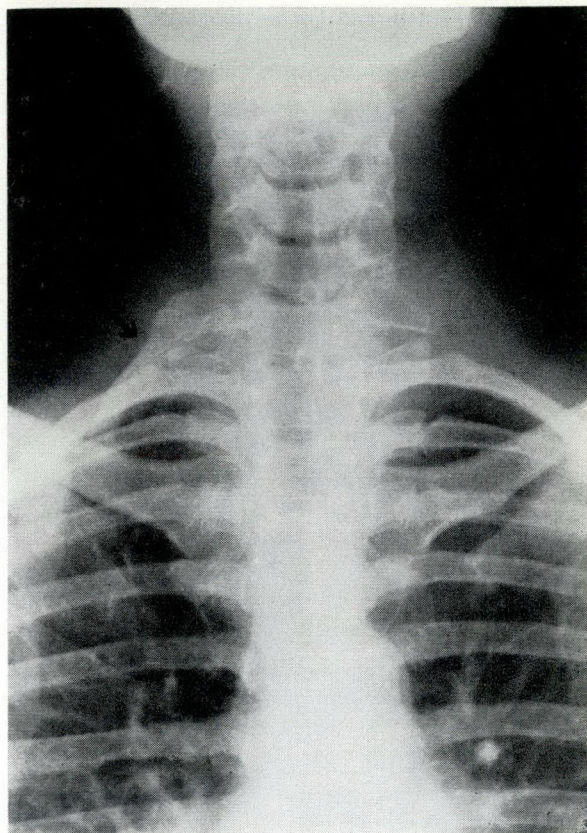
Mrs. W. Chest radiograph showing long cervical rib on right and rudimentary one of the left.
